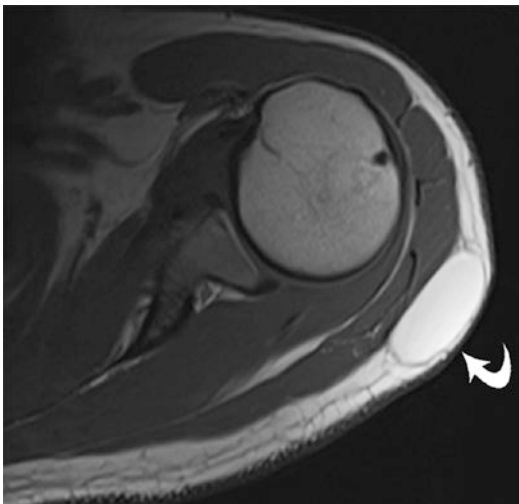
Subcutaneous lipoma: 38-year-old female with shoulder mass. Axial T1-weighted sequence (TR500, TE9.9) reveals an encapsulated subcutaneous lesion of high signal (curved arrow)
